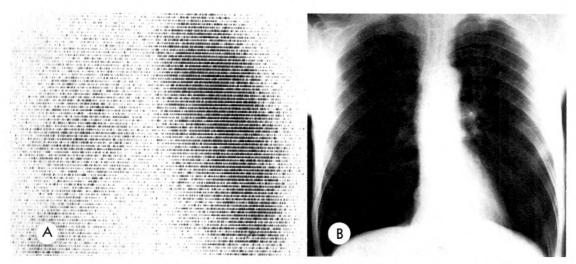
(A) Lung scan of a patient with chronic asthma and dyspnea on exertion. (B) Chest roentgenogram of same patient.
